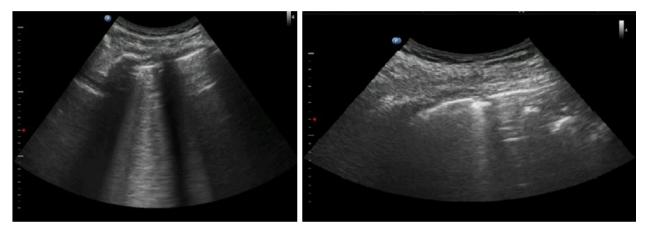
(a) Presence of multiple B-Lines in lung contusion: Vertical comet-tail artifacts originating from the pleural line, welldefined, hyperechoic, and moving with lung sliding, (b) Isolated peripheral parenchymal lesion on ultrasound.
